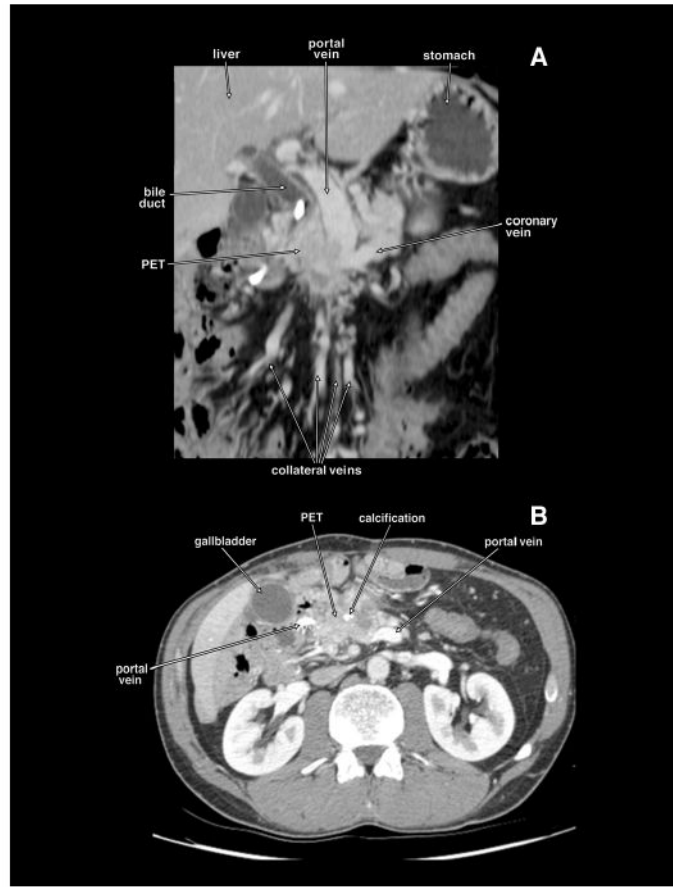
Coronal planar reformation (panel A) and axial tomogram (panel B) of a computed tomography of the same patient with a locally invasive non-metastatic pancreatic endocrine tumor (PET) obstructing the proximal portal vein. The PET has calcifications. There are extensive collateral veins because of the portal vein obstruction. This patient had the portal vein resected and reconstructed with autologous femoral vein.
